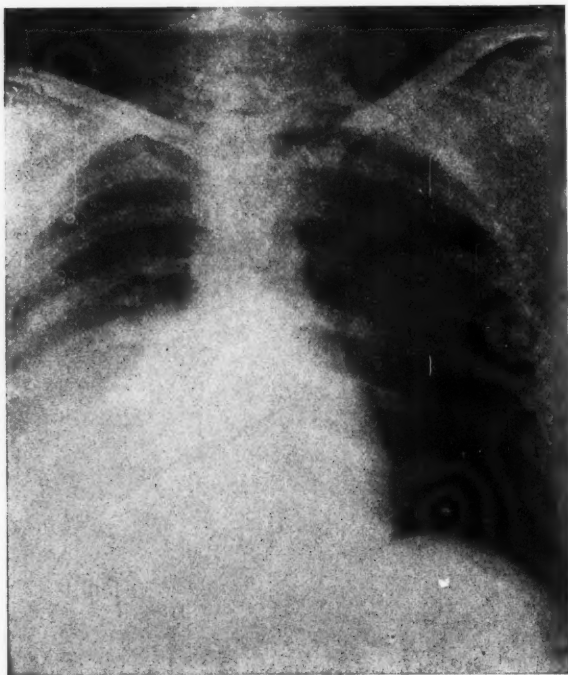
Case II. Roentgenogram taken on December 7th about eight days after diagnostic puncture of the pericardium. A large amount of fluid has leaked from the pericardial sac into the left pleural cavity by way of the puncture wound.
